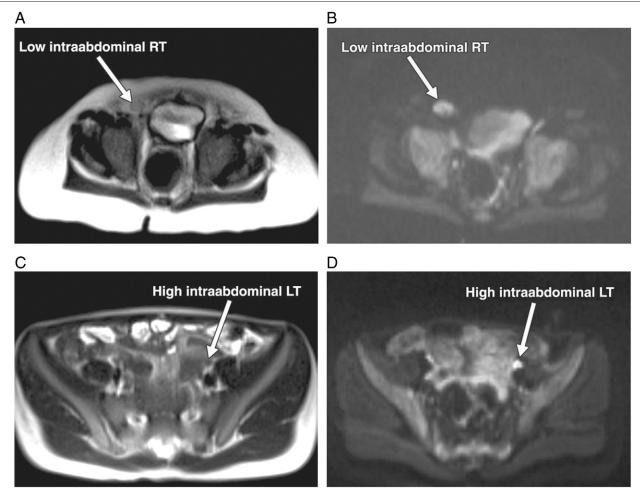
Magnetic resonance imaging evaluation of nonpalpable testes. A 10-month-old boy with low intraabdominal nonpalpable undescended right testis. A, T2-weighted magnetic resonance image shows isointense testis close to internal ring. B, Diffusion-weighted magnetic resonance image with a b value of 800 s/mm² shows markedly hyperintense testis. A 7-year-old boy with high intraabdominal nonpalpable undescended left testis. C, T2-weighted magnetic resonance image indistinctly shows isointense testis adjacent to iliac vessels. D, Diffusion-weighted magnetic resonance image with a b value of 400 s/mm² clearly shows markedly hyperintense testis among loops of small bowel. (Reprinted with permission from *Am J Roentgenol* 2010; 195:W268-273.) RT indicates right testis; LT, left testis.
